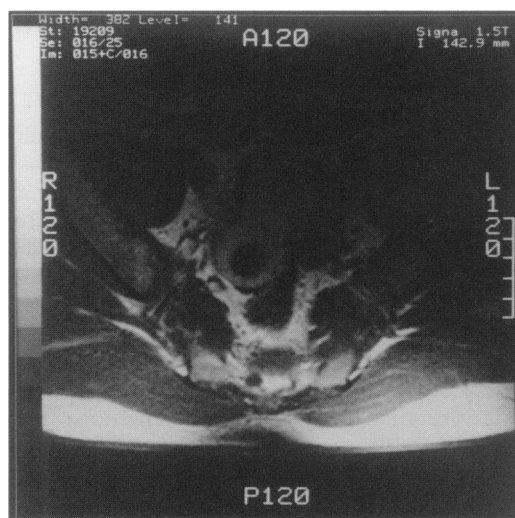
MRI scan of abdomen
